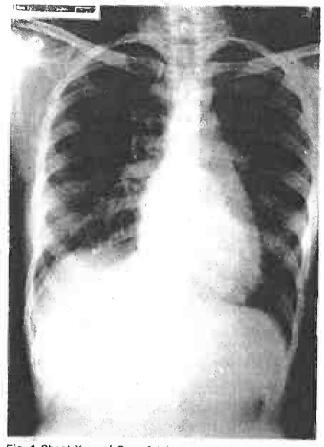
Chest Xray of Case 3 taken on admission. The heart size is minimally enlarged and changes of left heart failure are present.
